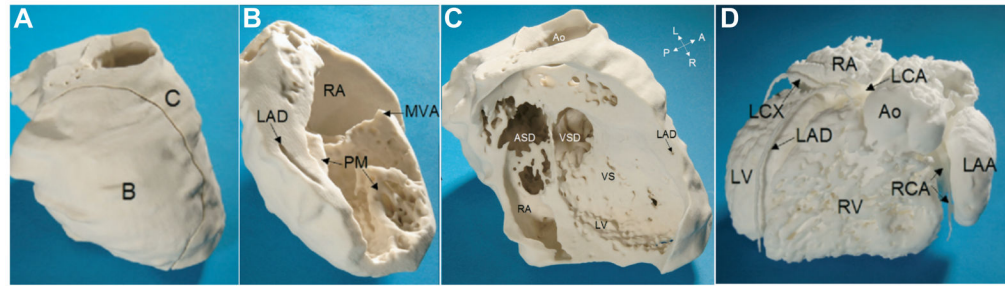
MRI-derived physical model of complex CHD
